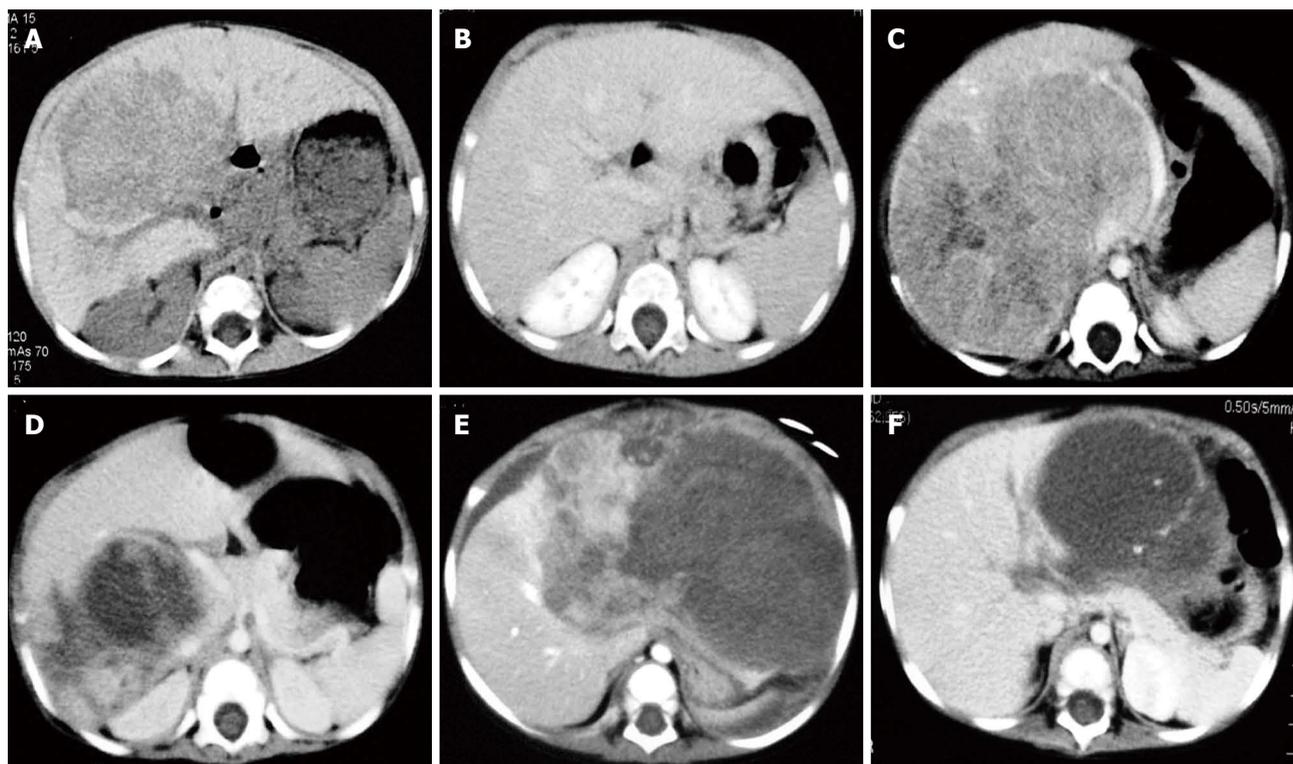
Each tumor location on contrast-enhanced computed tomography. A: Prechemotherapeutic computed tomography (CT) of case 1; B: Preoperative CT of case 1; C: Prechemotherapeutic CT of case 2; D: Preoperative CT of case 2; E: Prechemotherapeutic CT of case 3; F: Preoperative CT of case 3.
